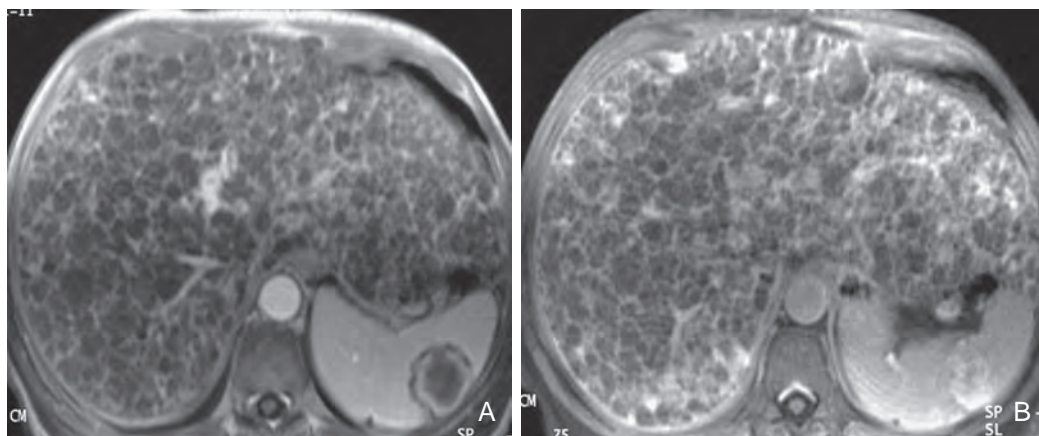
Angiosarcoma. Gadolinium-enhanced MR images obtained in the arterial (A) and portal venous (B) phases demonstrate the replacement of the liver parenchyma with numerous nodules. There is also an angiosarcoma in the spleen.
